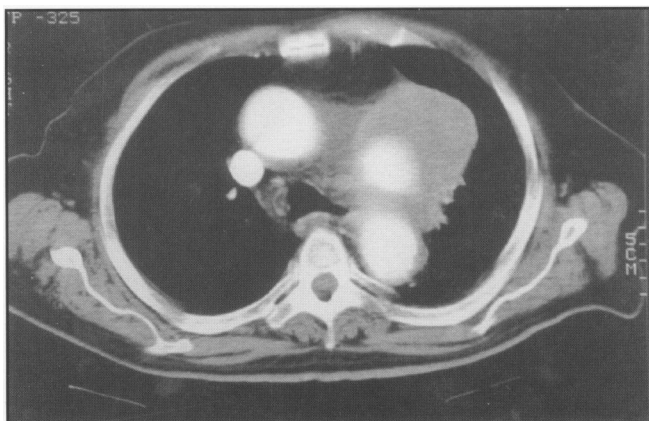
Contrast enhanced axial CT demonstrating large thoracic aneurysm at the level of the aortopulmonary window.
